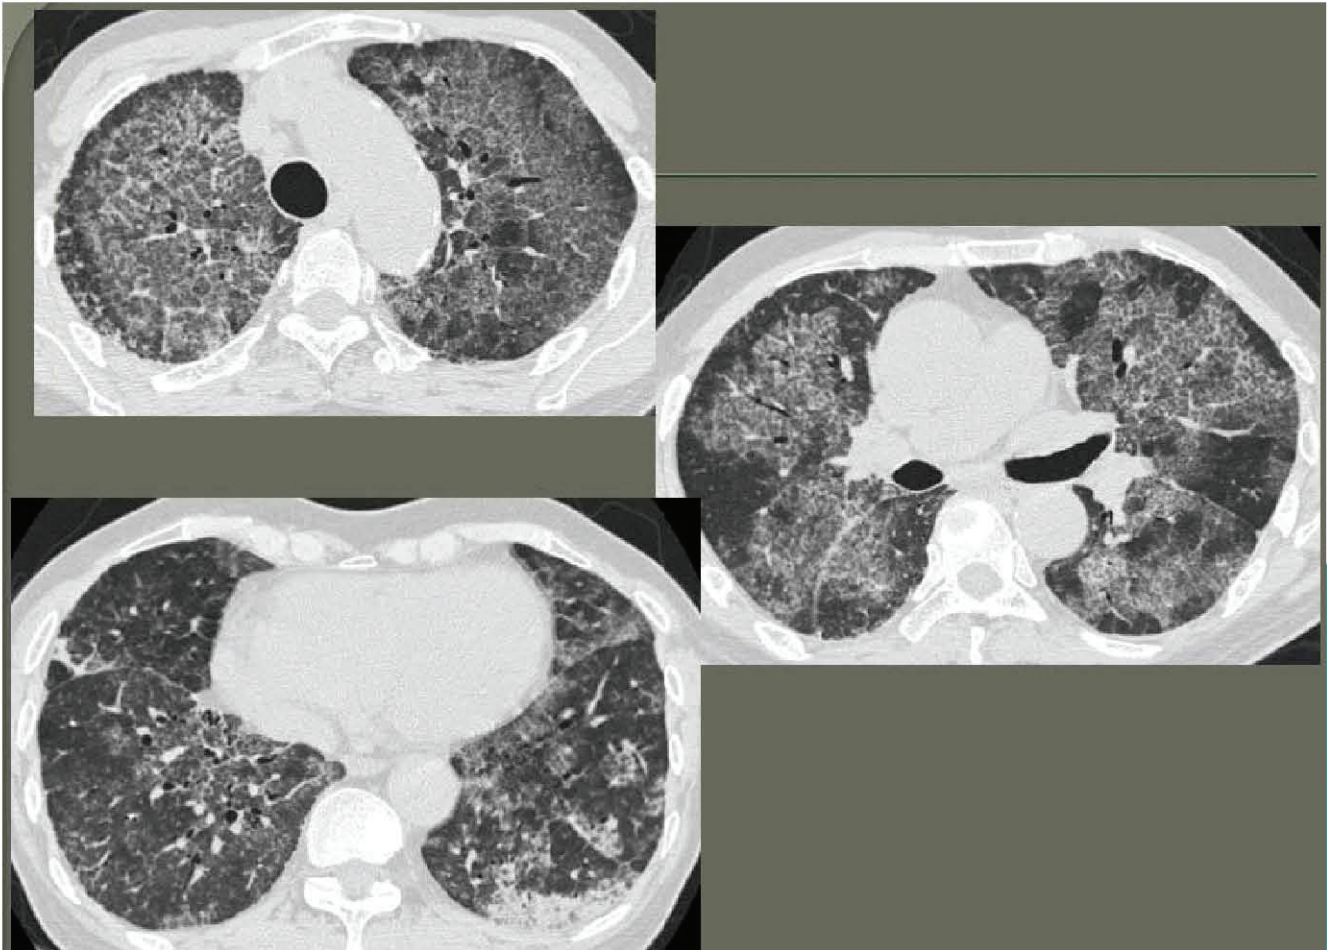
HRCT at 18 months after first bilateral WLL
